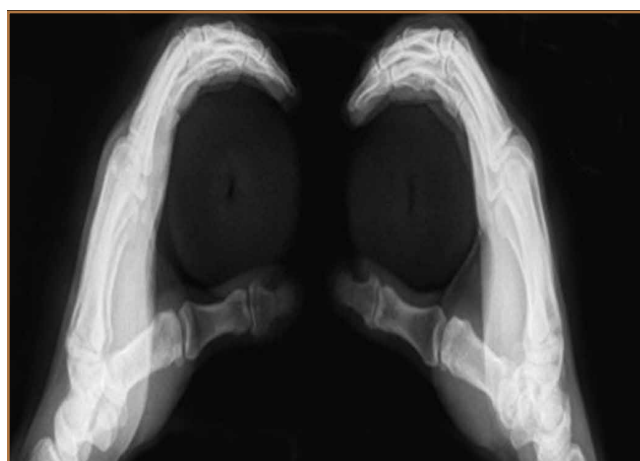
Normal case. Radiographs of uninjured hands (no instability).
